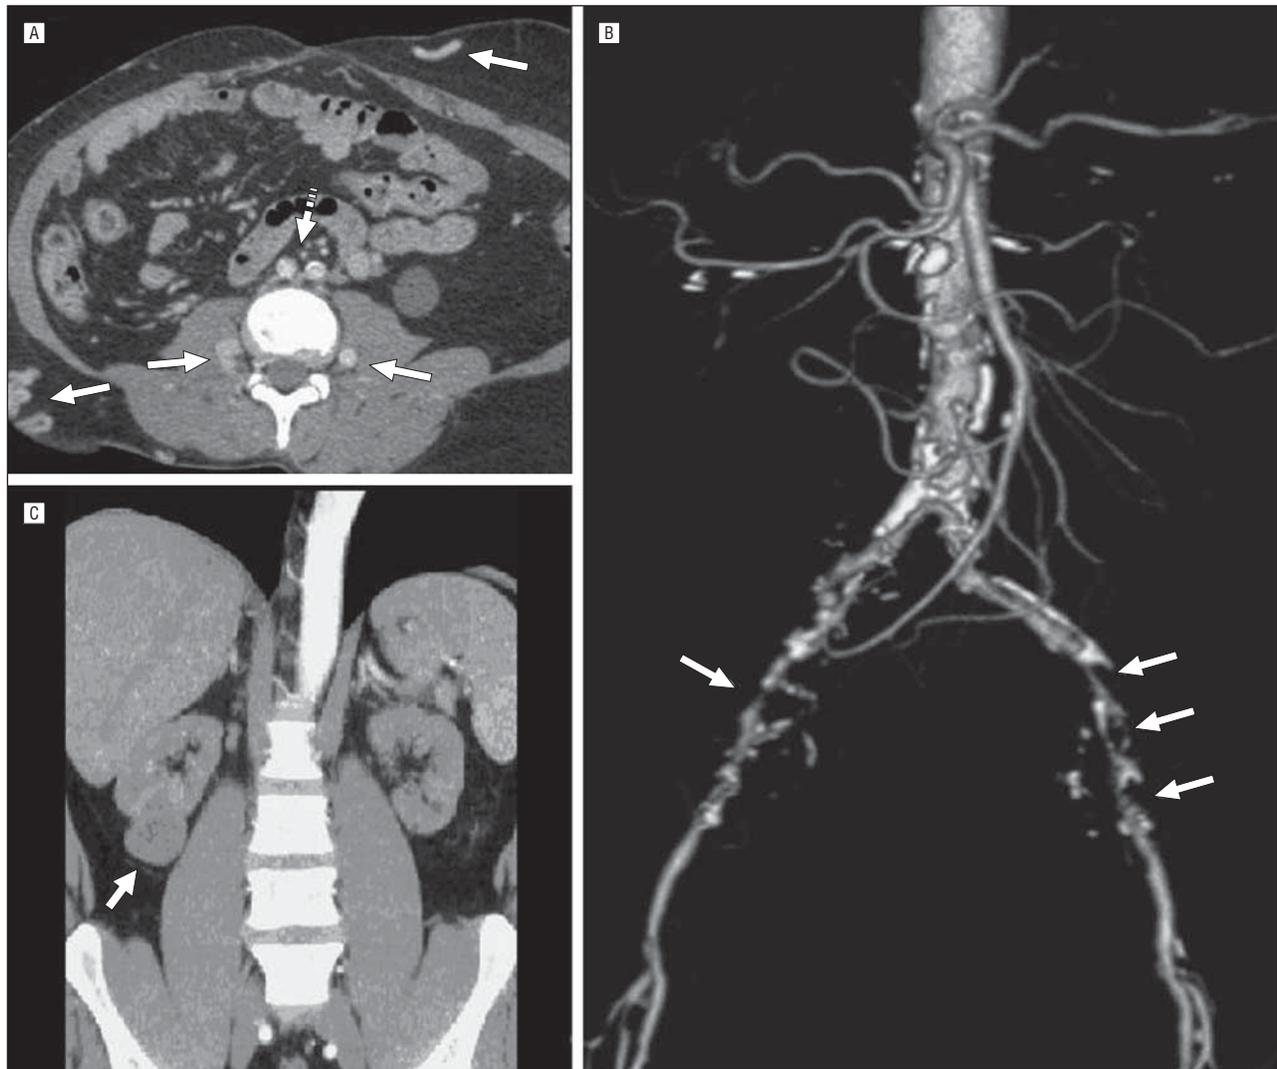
Representative computed tomography angiography (CTA) findings (digitally processed images). A, Axial computed tomographic image shows the presence of iliac arteries and occluded iliac veins (dashed arrow) with multiple collaterals (solid arrows). B, Severe bilateral iliac artery atherosclerosis (arrows). C, Renal cell carcinoma in lower pole of atrophic kidney (arrow).
